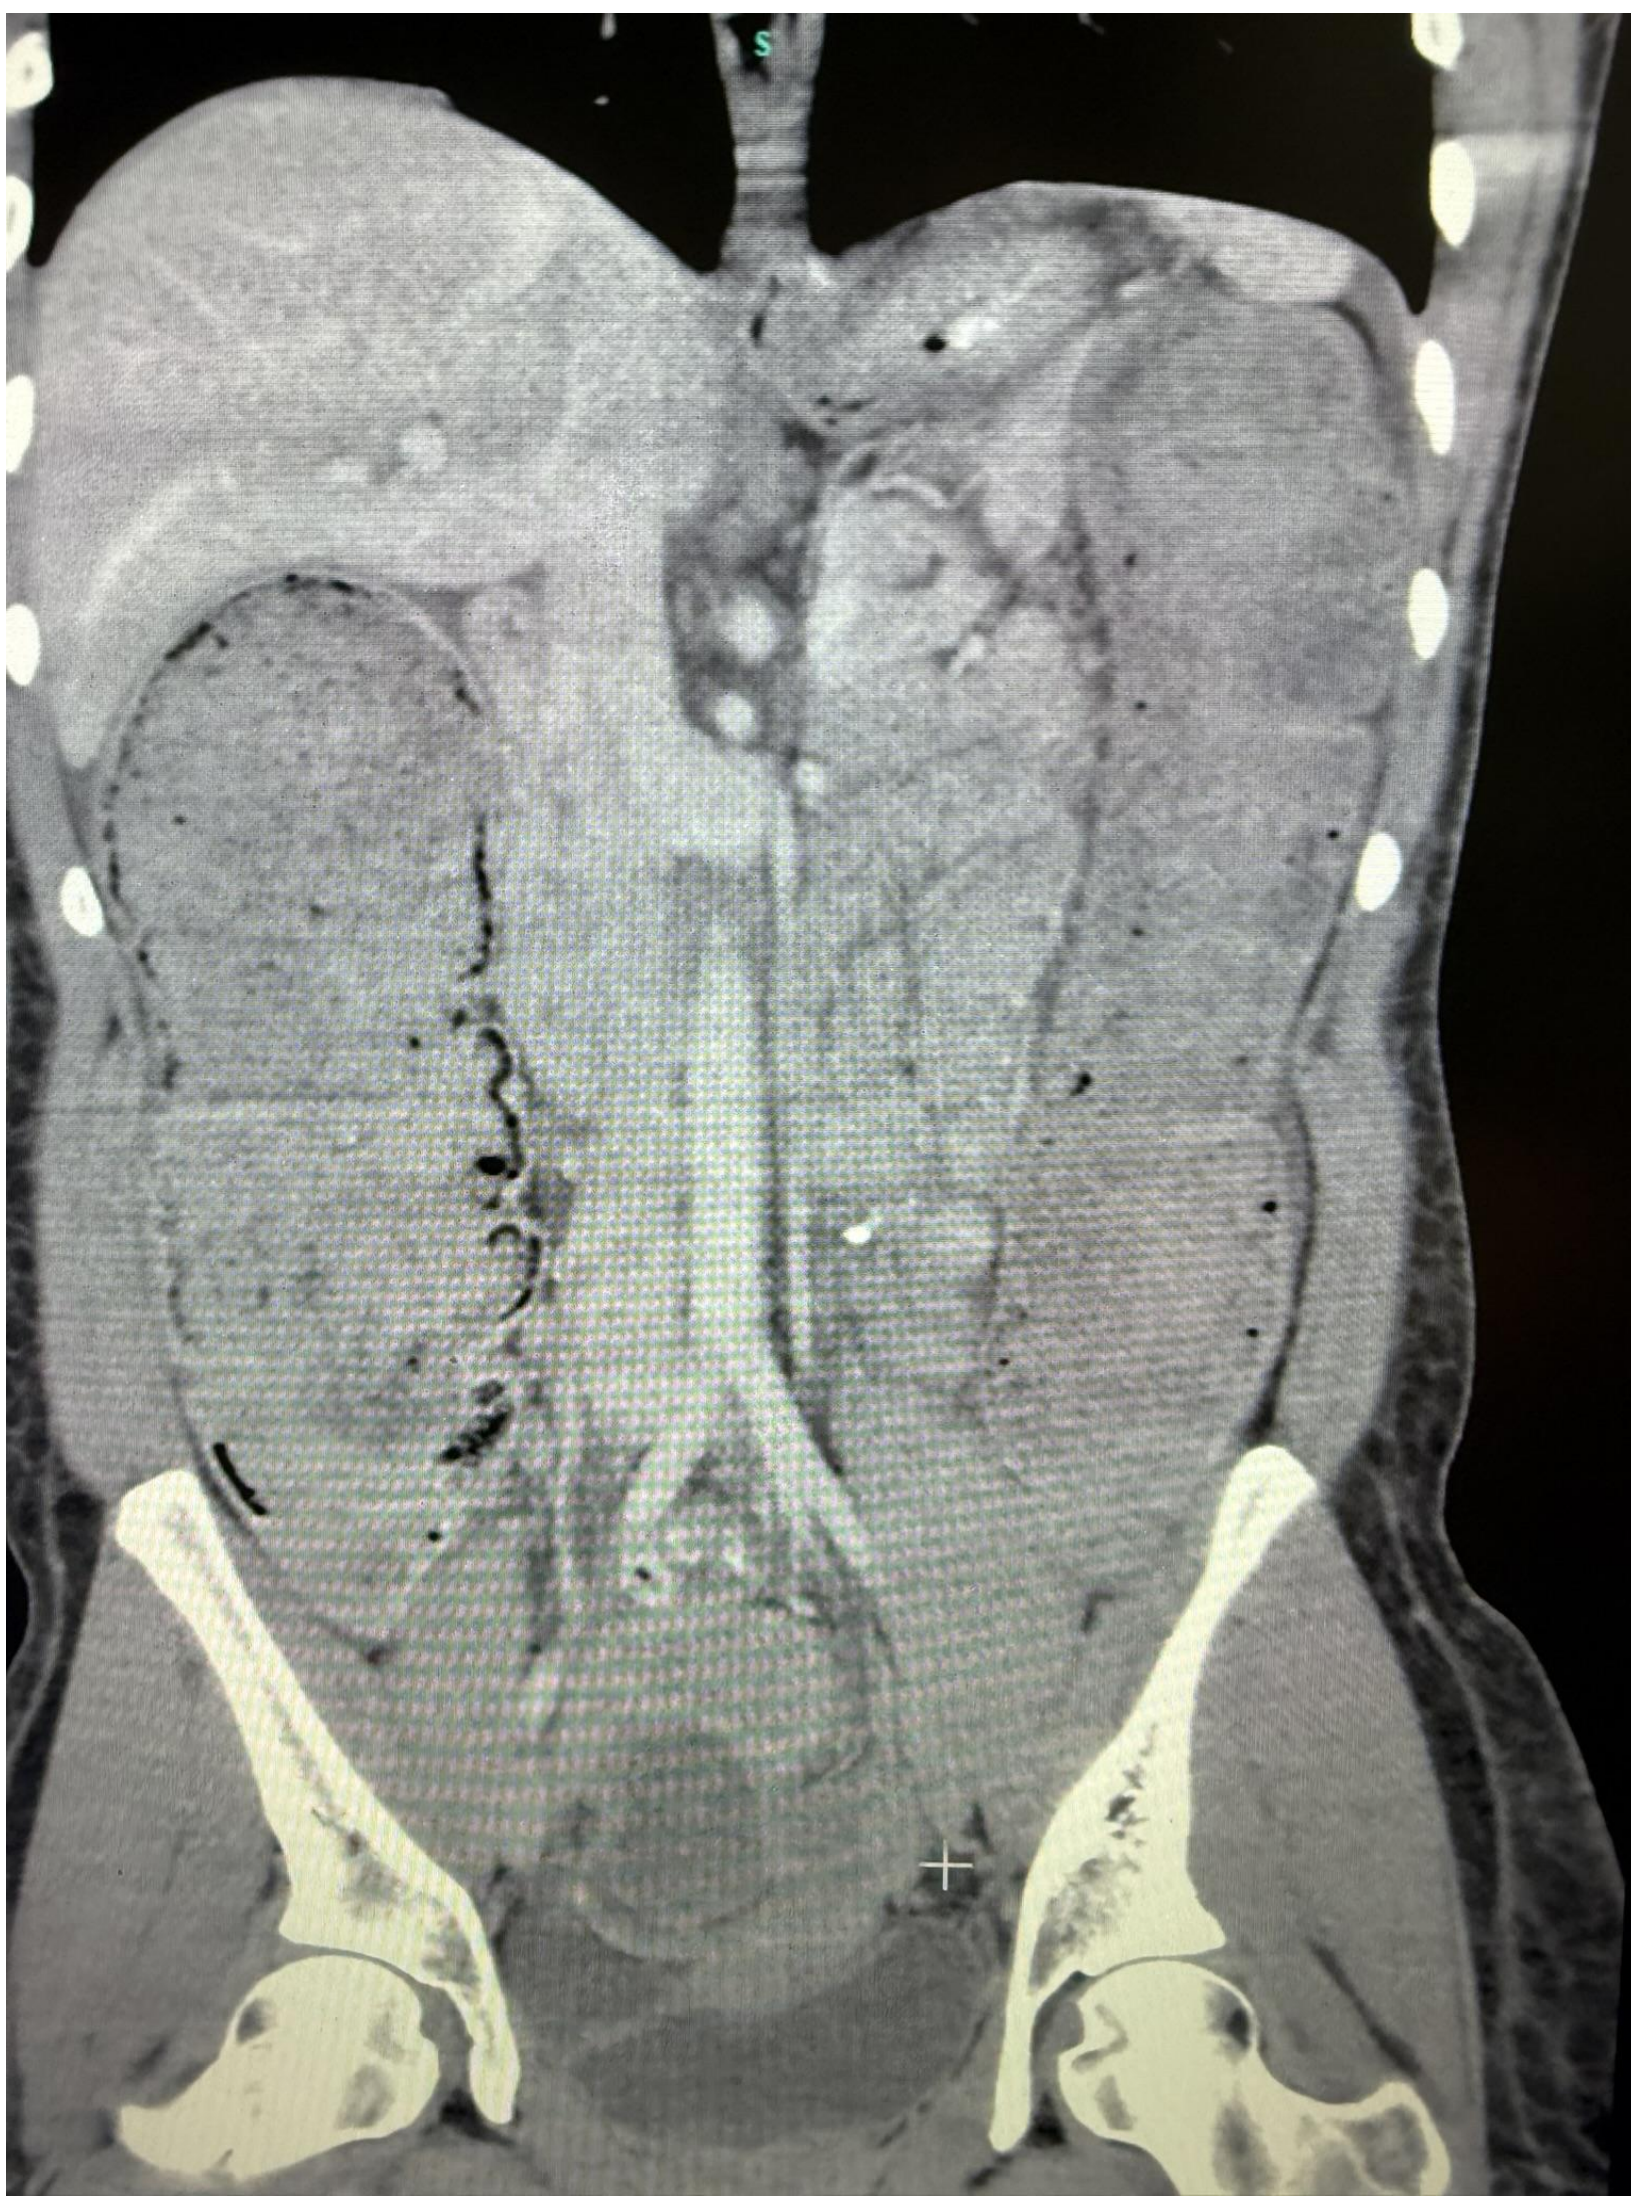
CT scan before the perforation. Note the significant stool burden.
